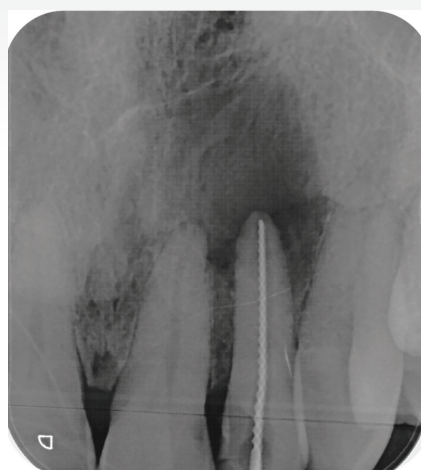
Master apical file periapical showing apical stop at working length
